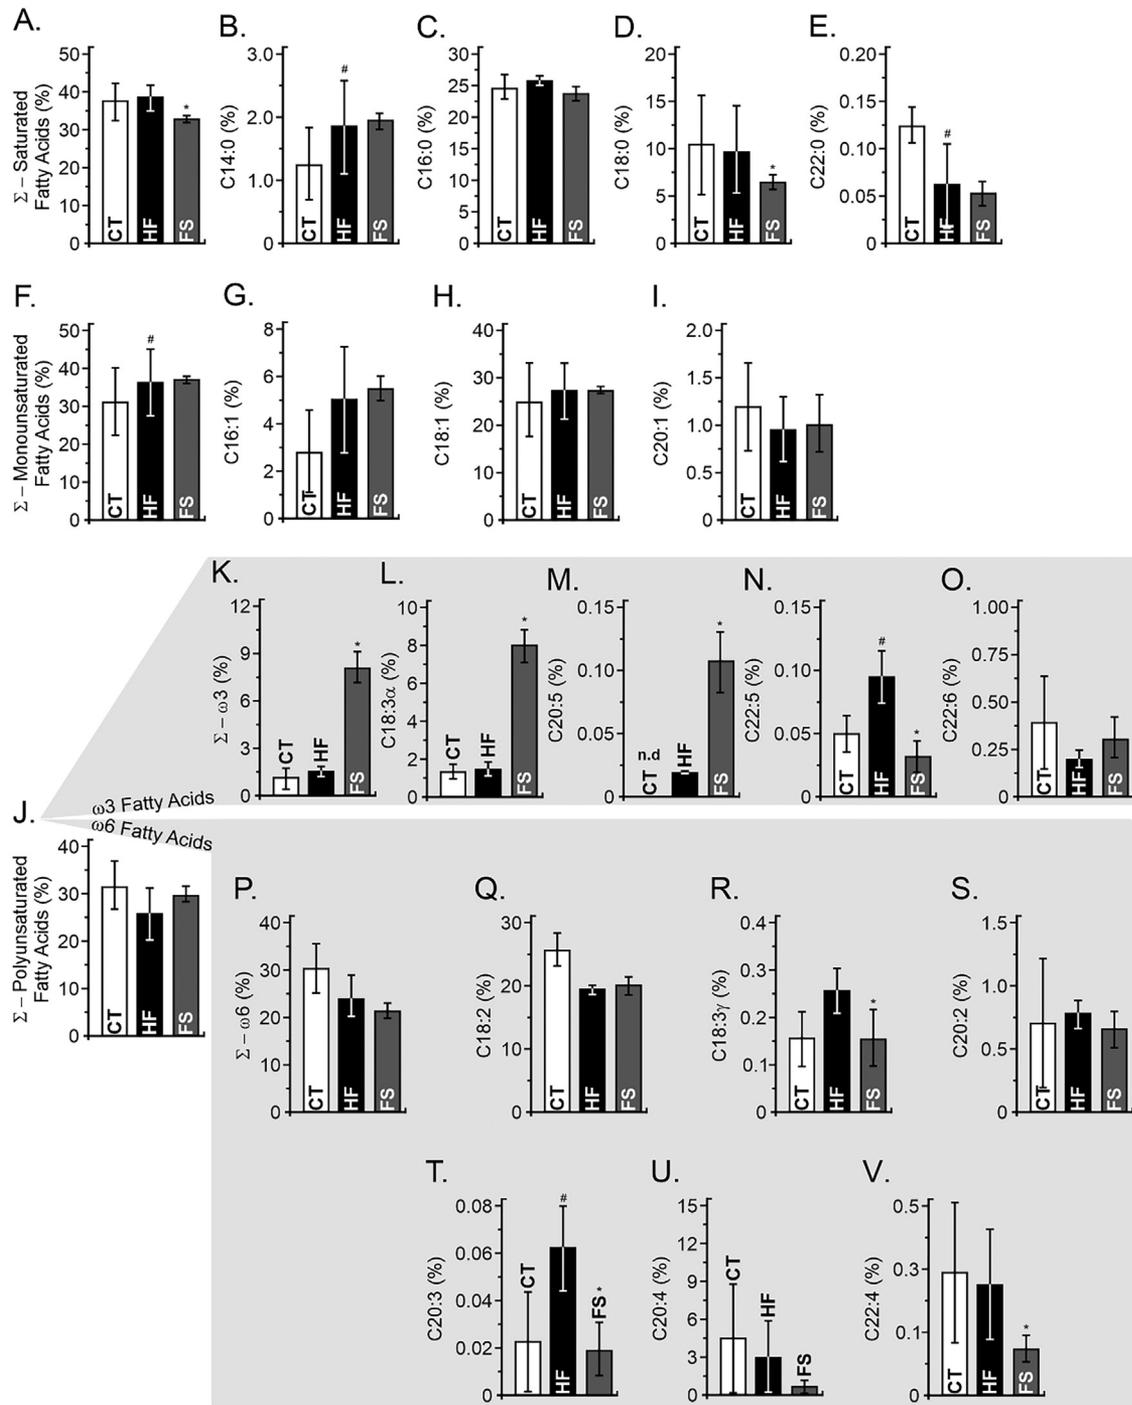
Fatty acid profile of the mesentery after short-term consumption of HF and FS. (A) Σ -Saturated fatty acids. (B) C14:0. (C) C16:0. (D) C18:0. (E) C22:0. (F) Σ -Monounsaturated. (G) C16:1. (H) C18:1. (I) C20:1. (J) Σ - Polyunsaturated fatty acids. (K) Σ - ω 3. (L) C18:3 α . (M) C20:5. (N) C22:5. (O) C22:6. (P) Σ - ω 6. (Q) C18:2. (R) C18:3 γ . (S) C20:2. (T) C18:3 γ . (U) C20:4. (V) C22:4. $P < .05$ #CT vs. HF and *HF vs. FS by Bonferroni's test.
